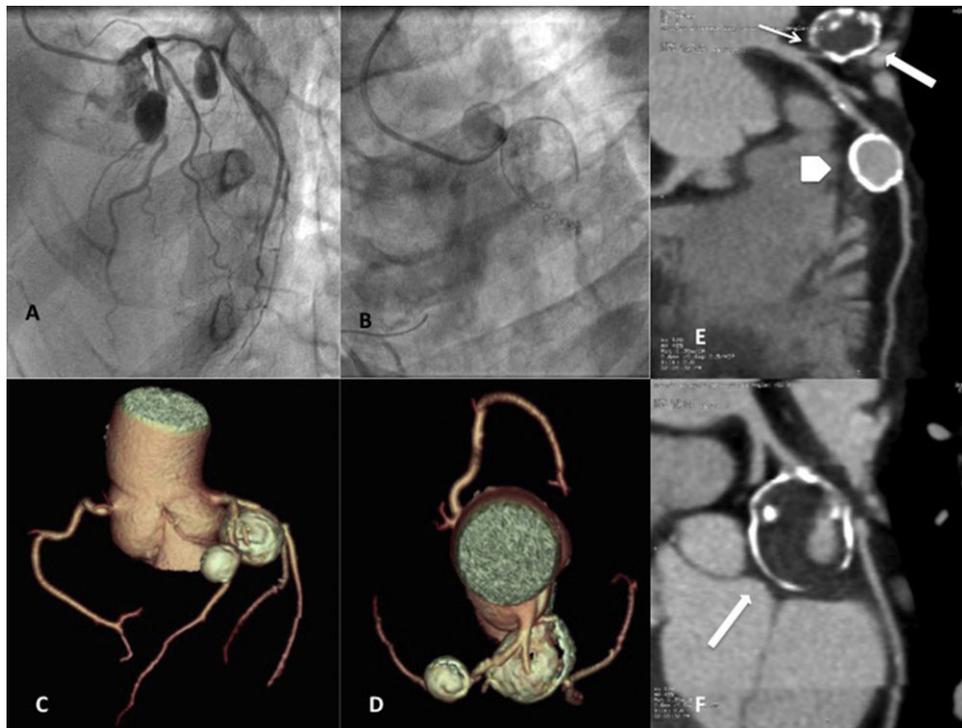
A and B, coronary angiography; aneurysmal dilatations in the proximal segment of the left anterior descending artery and the circumflex artery. C and D, computed tomography angiography showing 2 calcified, saccular, coronary artery aneurysms; the larger one is located in the circumflex artery. E and F, multiplanar reconstructions. Circumflex artery aneurysm, 30 × 24 mm in size (arrows), with a narrow neck (E, thin arrow), calcified wall (“eggshell” appearance), thrombus (interior, low-density area) and irregular residual lumen; 15 × 14 mm aneurysm in the left anterior descending artery (E, arrowhead), also showing a calcified wall.
